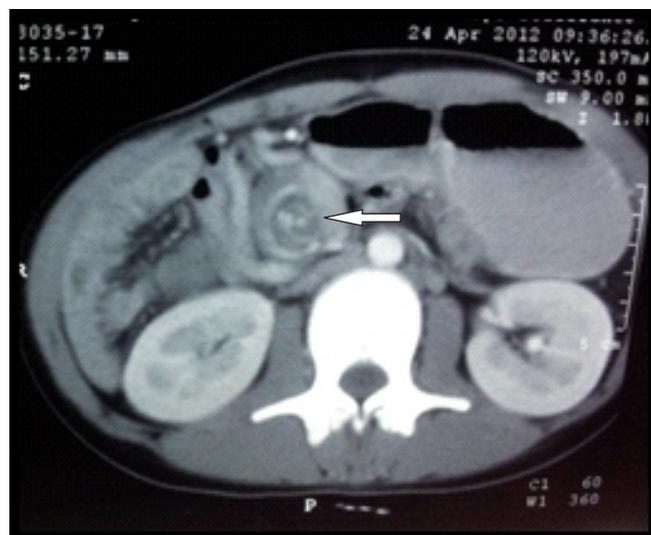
Contrast-enhanced CT scan of abdomen showing “whirlpool sign” (arrow) suggestive of midgut volvulus.
